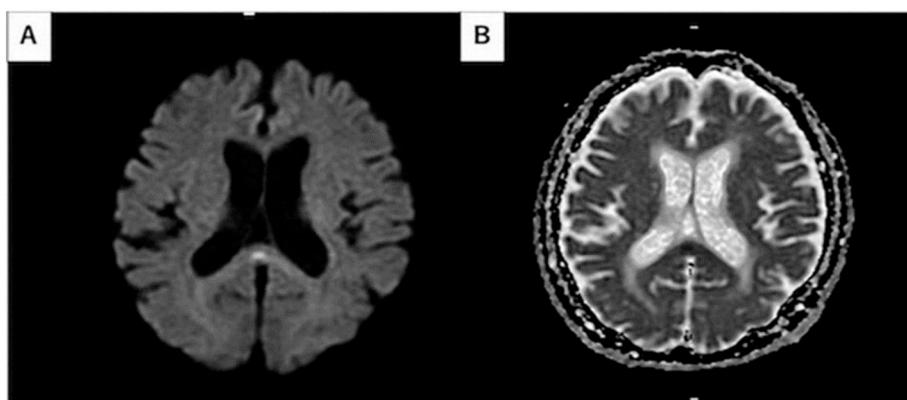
Diffusion weighted image (DWI) shows high signal intensity in the splenium of corpus callosum. Apparent diffusion coefficient (ADC) map demonstrates correlated slight decrease in ADC. From Hayashi M et al. [160]
